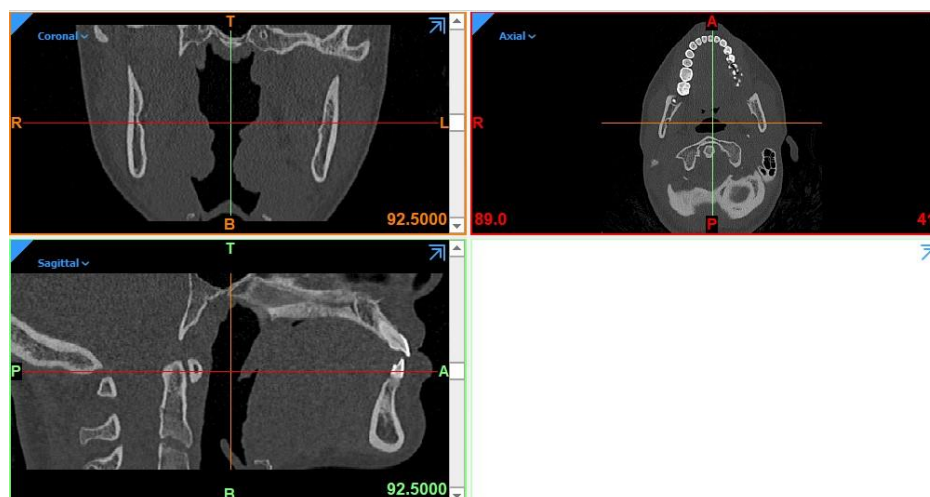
Axial, coronal, and sagittal CT views of an intact human mandible captured with a 1 mm interslice thickness, representing the first step in the imaging process
